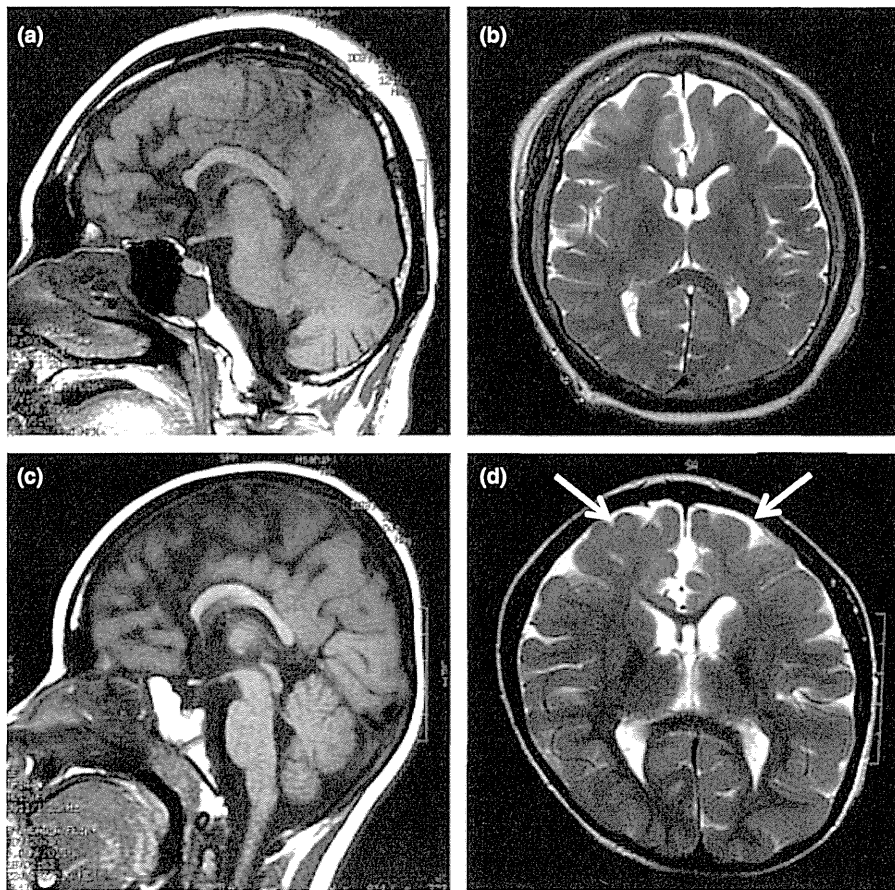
Brain magnetic resonance imaging (MRI) scans of the two patients with *FOXG1* mutations. Patient 1 (aged 33 years during MRI) has hypoplasia of the frontal lobe and corpus callosum (a and b). Patient 2 (aged 8 years during MRI) has delayed myelination in the frontal lobe (arrows) with hypoplasia of the corpus callosum and frontal lobe (c and d). Both have a low forehead which indicates a hypoplastic frontal lobe. (a) and (c) T1-weighted sagittal images; (b) and (d) T2-weighted axial images.
